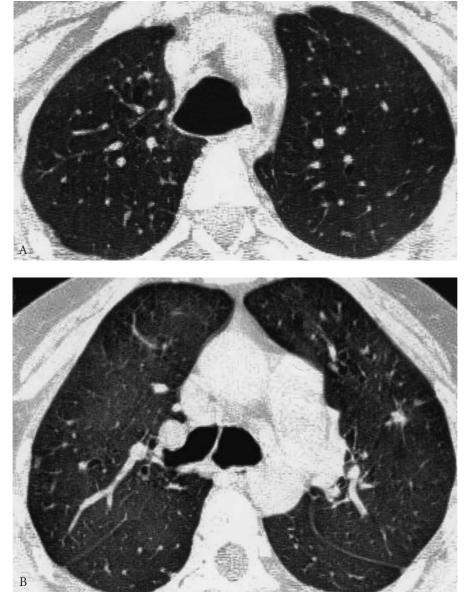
Computed tomography scans showing tracheobronchomegaly in a 44-yearold male, with dyspnea for 10 years, much worse in the last year. There is massive dilation of the trachea (A) with elongated membranous wall and of main bronchi at the carina (B). More marked bronchiectatic changes were present at both lung bases.
